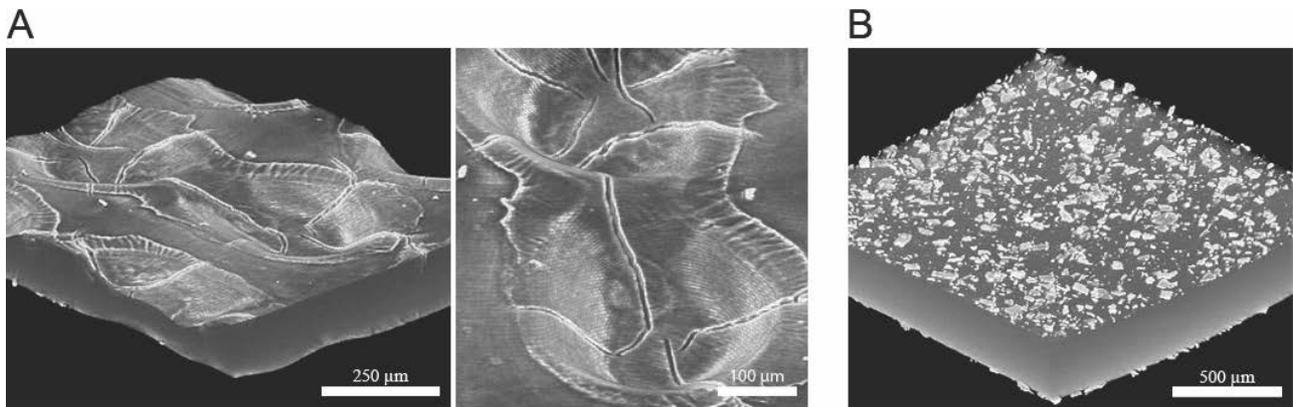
The PLCL (A) and PTMC (B) membranes were imaged with micro CT showing the surface characteristic of the membranes. The maximum diameter of the pit in PLCL membrane is 400 µm. The granules on the PTMC membranes are glucose, which makes the membranes easier to handle.
